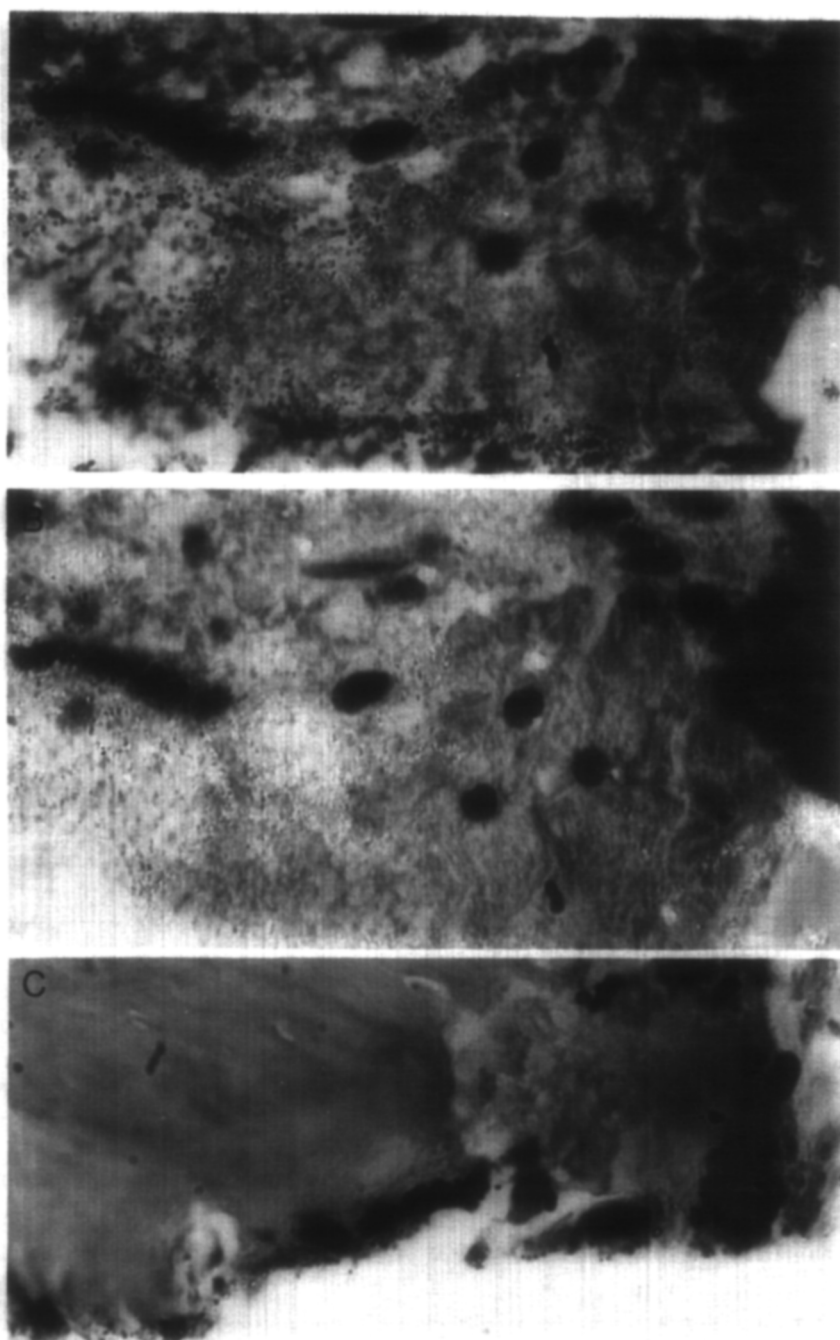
Case 214 (same as in Fig. 1). *A*, Root canal sealer in periapical tissue. *B*, Exactly same area as in *A*, but photographed in polarized light. Root canal sealer is evenly dispersed, not aggregated together like the brown pigment in Fig. 3, *B-E*, and easily distinguishable from the bacterial clusters shown in Fig. 7. *C*, Apical dentin fragment with sealer particles and resorbing cells. The location of the particles is evidence that this is their location in vivo since the particles are not on the dentin. (Original magnifications, $\times 1,000$.)
